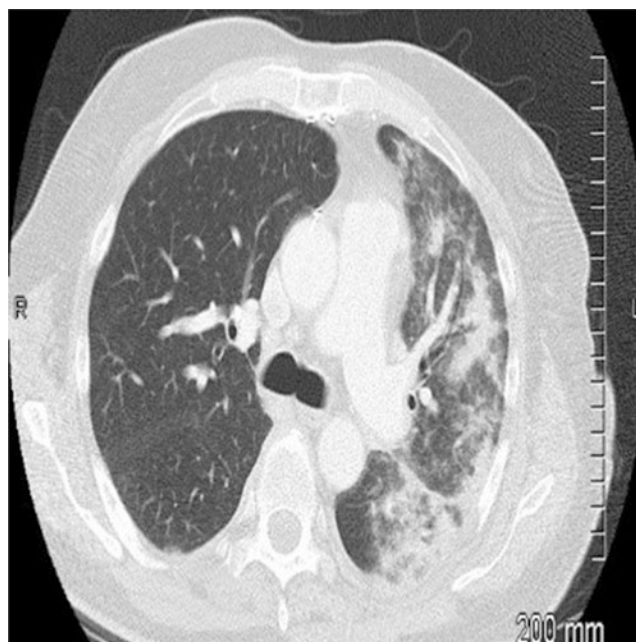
Chest CT demonstrating patchy, bilateral ground-glass opacities, consolidation, and nodules in the upper lobe
